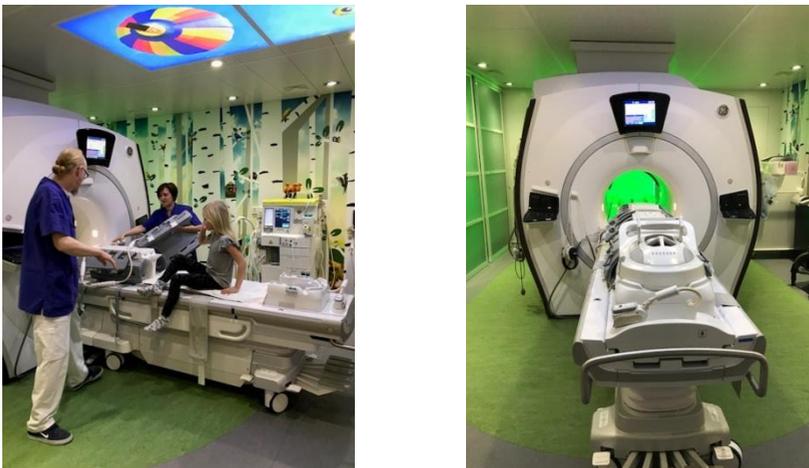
MRI at Queen Silvia Children's Hospital
